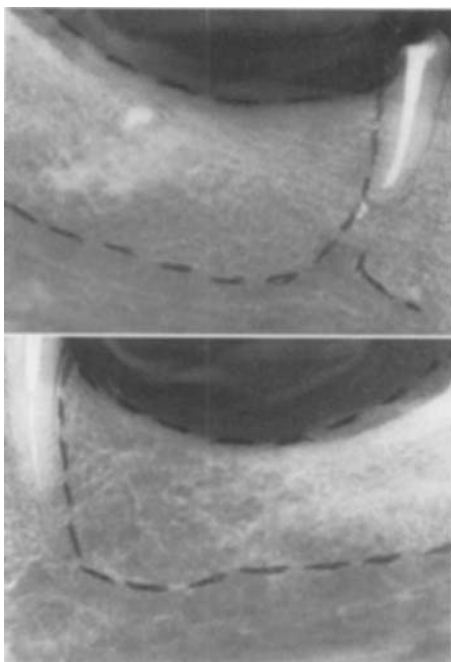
■ Available bone outlined on periapical radiographs.
